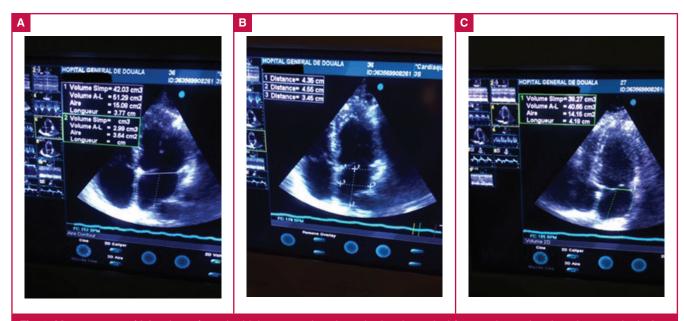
Measurement of LA volume from the biplane area–length method, using apical four- and two-chamber views to obtain A1, A2 and the longitudinal diameter (L) (distance 2 in B) (courtesy of Doula General Hospital).
